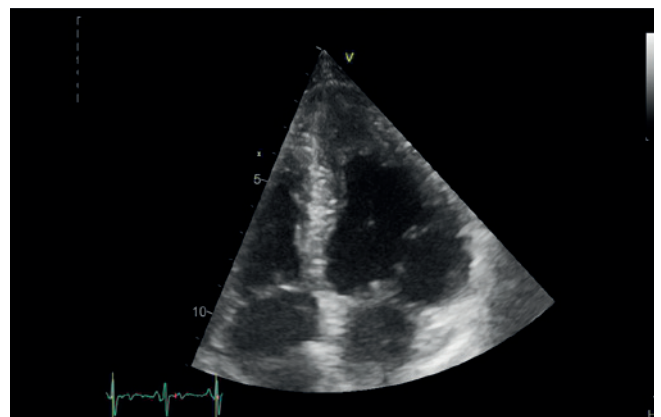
Apical 4 chamber image showing marked left ventricular hypertrophy extending from the mid-cavity to the apex, with an "ace of spades" appearance and near-complete obliteration of the apex during systole, mimicking apical hypertrophic cardiomyopathy due to apical oedema.
